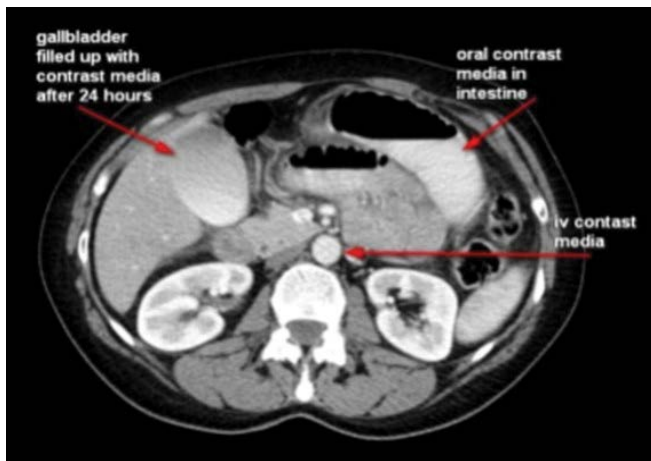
Gallbladder contrast CT, day 2.
